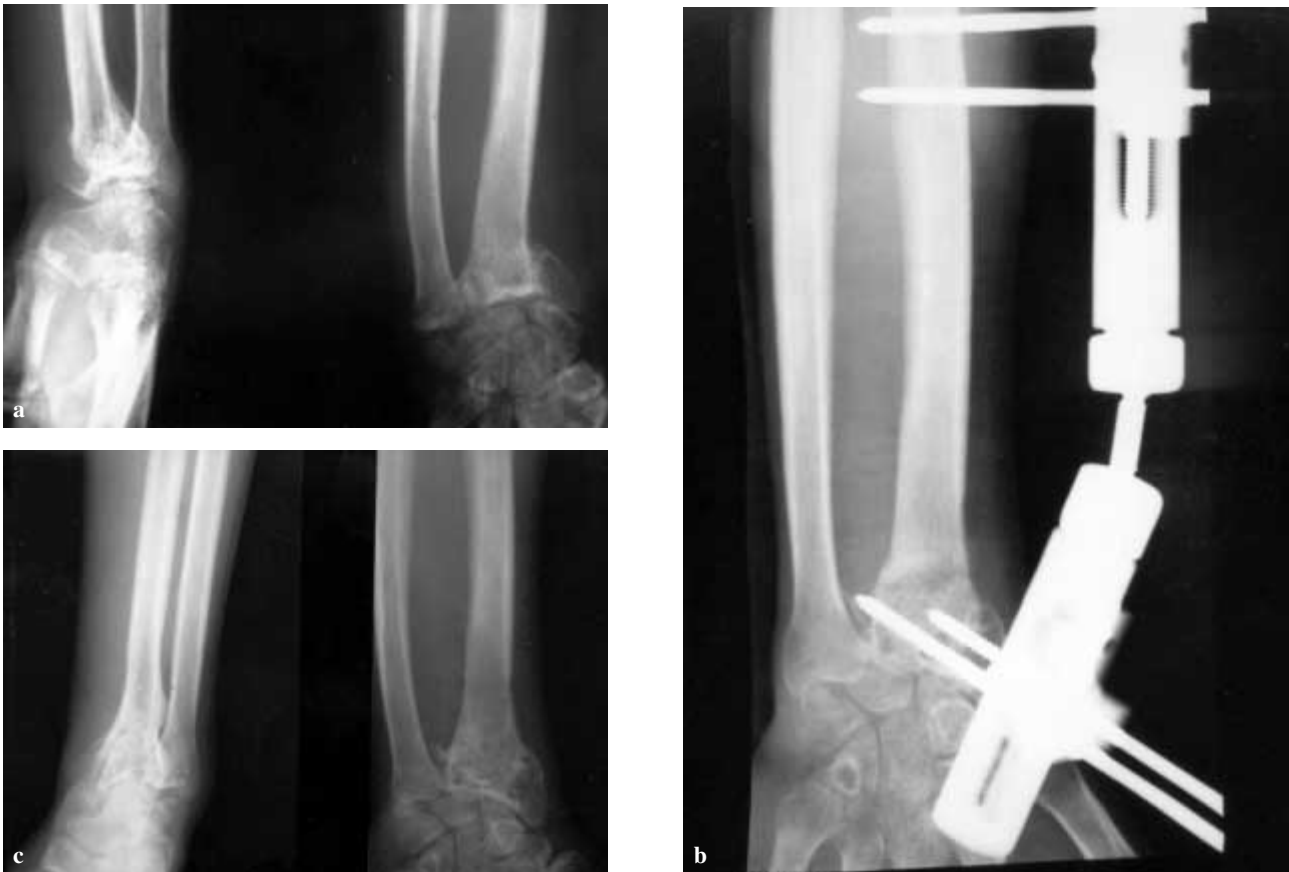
Preoperative anteroposterior and lateral X-ray of a patient with malunion in the distal radius and nonunion in the diaphysis associated with a segmental fracture in the radius (case 4). b : Ulnar translation of the distal fragment occurred during distraction. c : Anteroposterior and lateral X-ray 6 months postoperatively. Radio-ulnar index : 0 mm. Volar inclination : 8°. Ulnar inclination : 19°. Diaphyseal nonunion healed.
